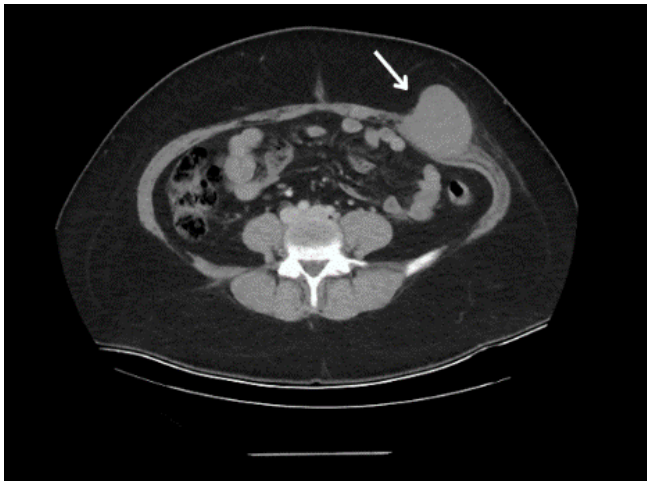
Contrast-enhanced computed tomography of the mass on admission (arrow).
